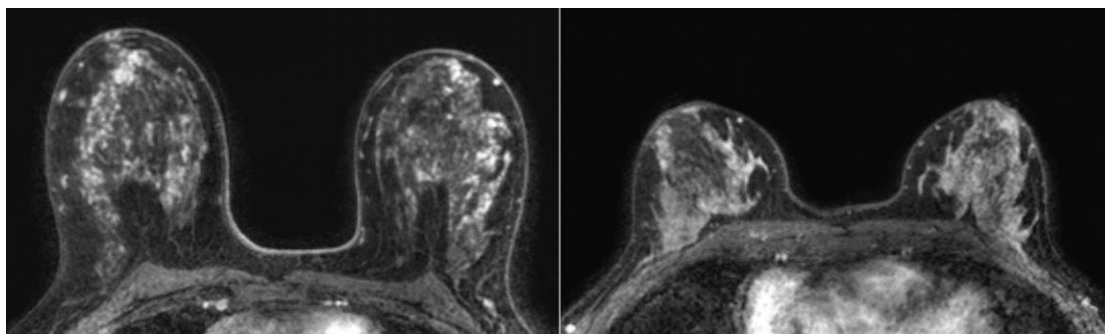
Representative dynamic contrast-enhanced MRIs (transverse plane) in patients in the low and high tertiles of volume of enhancing parenchyma. Left: Baseline MRI in a 50-year-old female with a body mass index (BMI) of 23 and ‘marked’ background parenchymal enhancement (BPE) who was stratified into the high tertile of volume of enhancing parenchyma. Cancer was detected on MRI in the second screening round. Right: A 51-year-old female with a BMI of 24 and ‘marked’ BPE who was stratified into the low tertile of volume enhancing parenchyma. No cancer was detected during 6 years of follow-up. Note, differences in high and low volumes of enhancing parenchyma are not visible to the naked eye on MRI.
